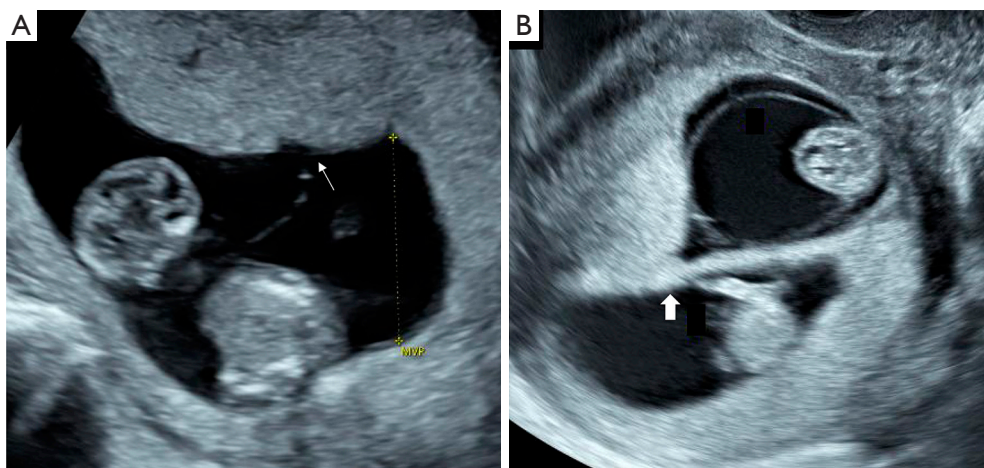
First trimester ultrasound appearance of a monochorionic and dichorionic twin pregnancy. A monochorionic twin pregnancy is diagnosed when the membrane is thin and inserts directly on the placental surface (T-sign) as indicated by a thin arrow (A). A dichorionic twin pregnancy is diagnosed when the intertwin membrane is thick with intervening placental tissue at its base (λ -sign) as indicated by a thick arrow (B).
